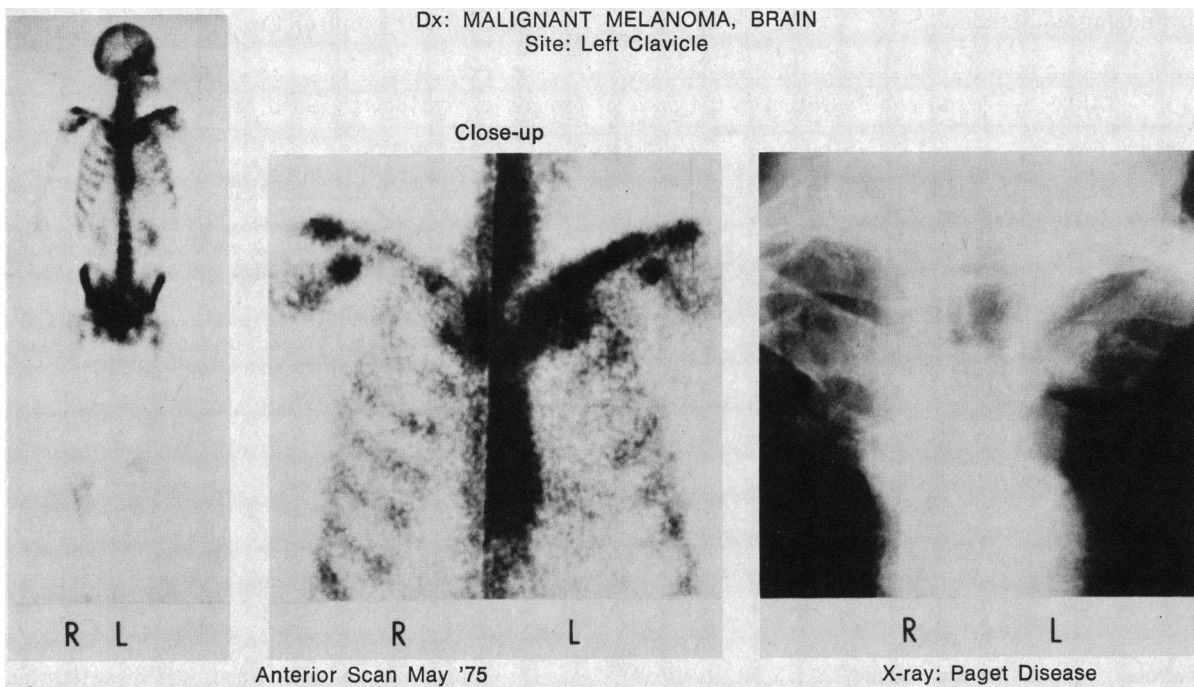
Bone scan of a 74-year-old man with malignant melanoma of the brain. There is increased activity involving the left clavicle. The radiograph showed cortical thickening, classic of Paget disease.
